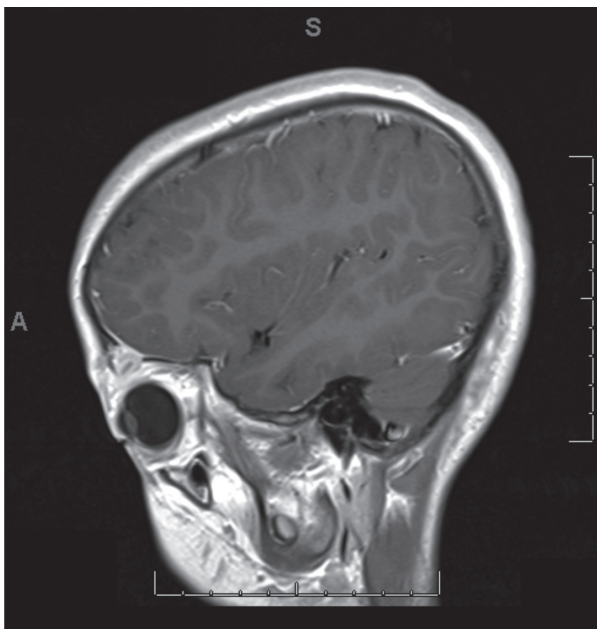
Transverse cut of brain MRI showing left superior orbital mass with adjacent dural enhancement
